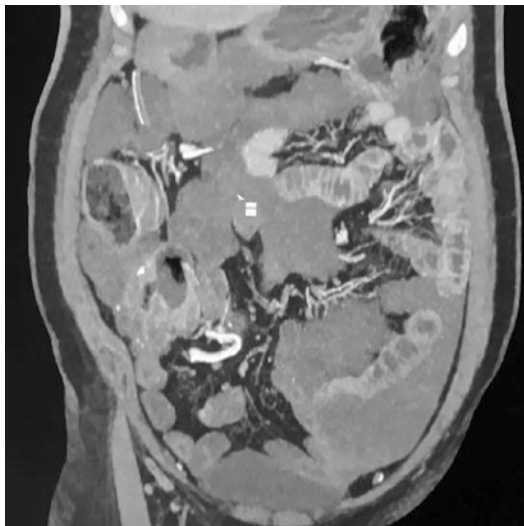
CT scan showing mucinous tumour involving the serosa of the small bowel at multiple sites
